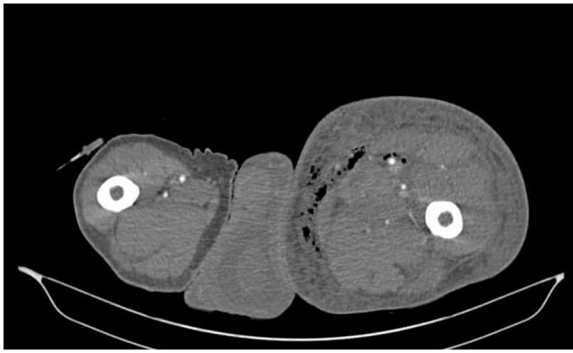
Computed tomography (CT) angiography of the lower limb: subcutaneous emphysema involving the soft tissues of the left thigh.
